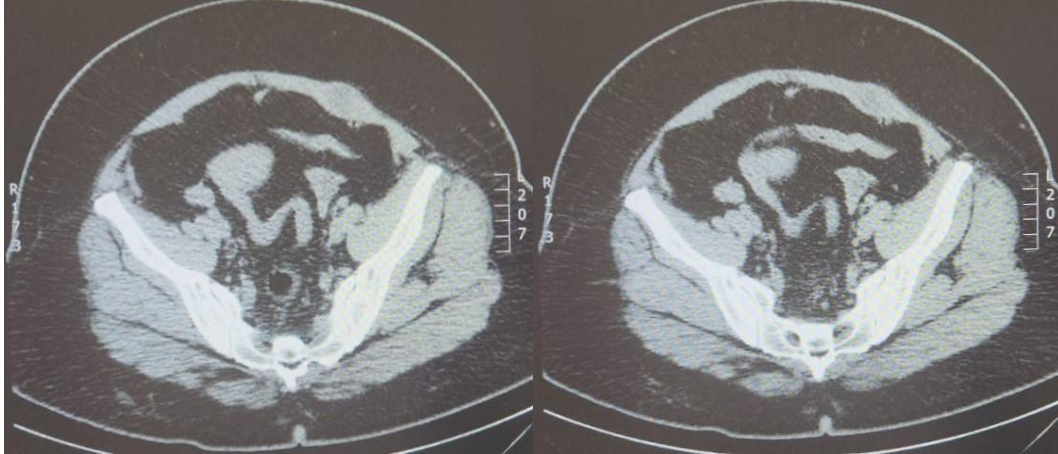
Axial CT showing a tumor in the left rectus abdominis, located in the lower third. Source: Direct.
